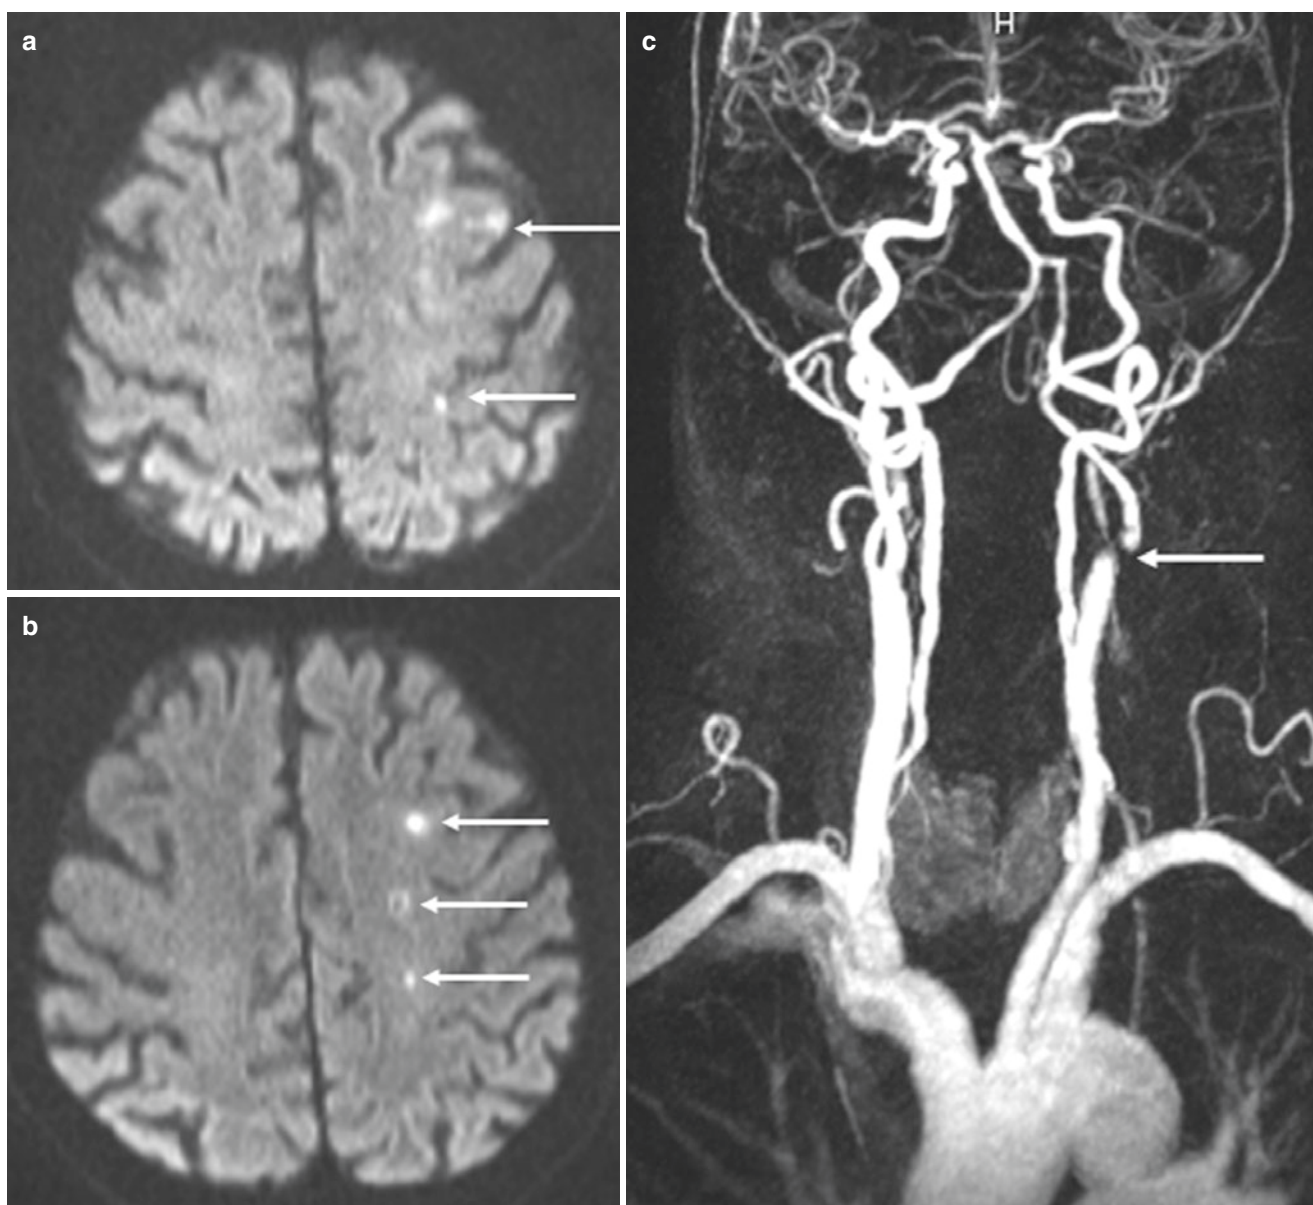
Diffusion-weighted MR images (a–c) showing multiple embolic lesions throughout the left hemisphere (arrows), partially involving hemodynamic border zones. Contrast-enhanced magnetic
